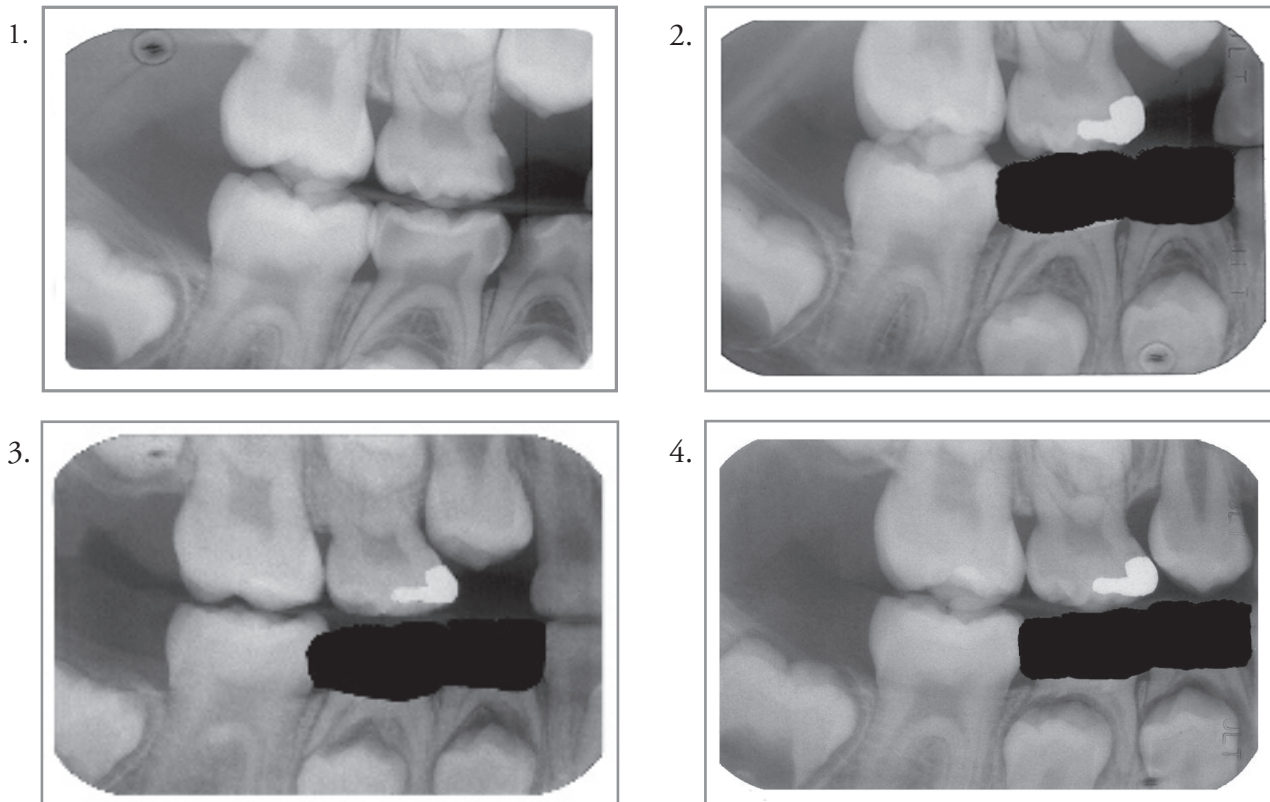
Pre-treatment radiograph.\*
